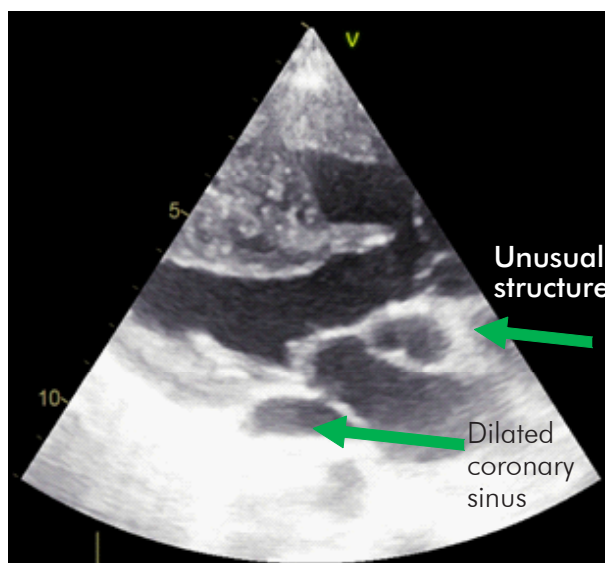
PLAX view without doppler
